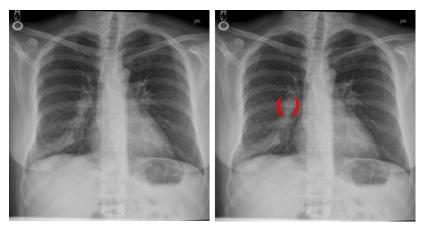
Chest X-ray demonstrates an opacity in the right lower lobe. The right hilum is biconvex & masslike in shape. This finding is suggestive of post-obstructive pneumonia versus pneumonia with reactive lymphadenopathy Image courtesy of the University of Massachusetts Medical School, Department of Radiology.
